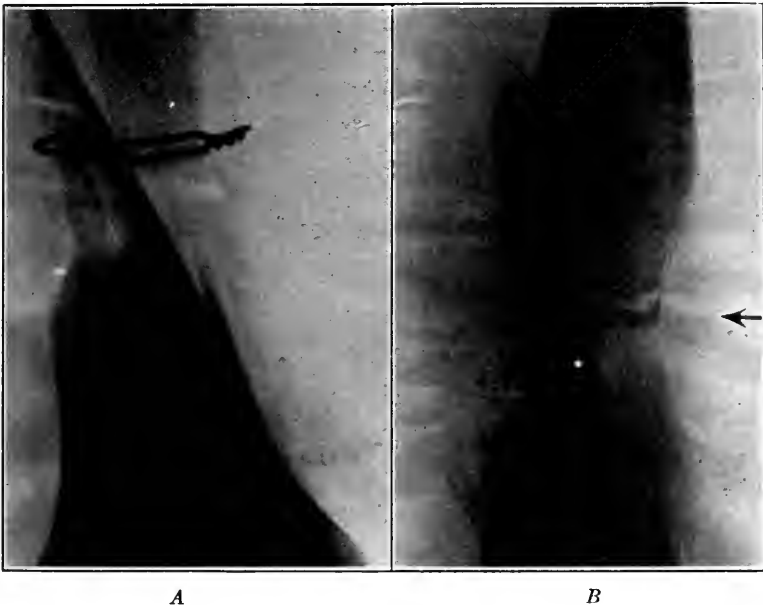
X-ray showing the effects of an encircling wire in the presence of chronic sepsis. *A*, silver wire encircling the lower end of the upper fragment and the upper end of a spike from the lower fragment. *B*, the arrow indicates a sequestrum separated by the encircling wire, which had cut off its blood supply; shows excessive callus formed in the presence of sepsis when the periosteum has been loosened and a gap left between the bony cortex and the periosteal surface. Encircling wires should not be used in open fractures.
